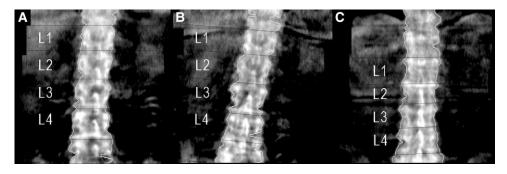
Dual-energy x-ray absorptiometry images of the lumber spine. A, At presentation at our outpatient clinic. B, One month before starting and C, 1 month after finishing 1-year treatment with romosozumab.
